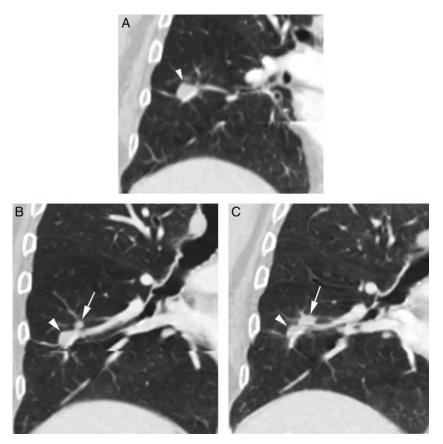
Local recurrence following percutaneous ablation. A, Coronal CT image obtained 1 year following percutaneous ablation of a right lung neoplasm demonstrating an opacity (arrowhead) at the treatment site, which is smaller than the treated lesion, consistent with an adequately treated lesion. B, CT obtained 1.5 years following ablation shows a new small nodule (arrow) immediately superior to the posttreatment opacity (arrowhead), suspicious for local recurrence. C, CT obtained 8 weeks after (B) showing further growth in the new nodule (arrow), immediately superior to the posttreatment opacity (arrowhead), consistent with local recurrence.
